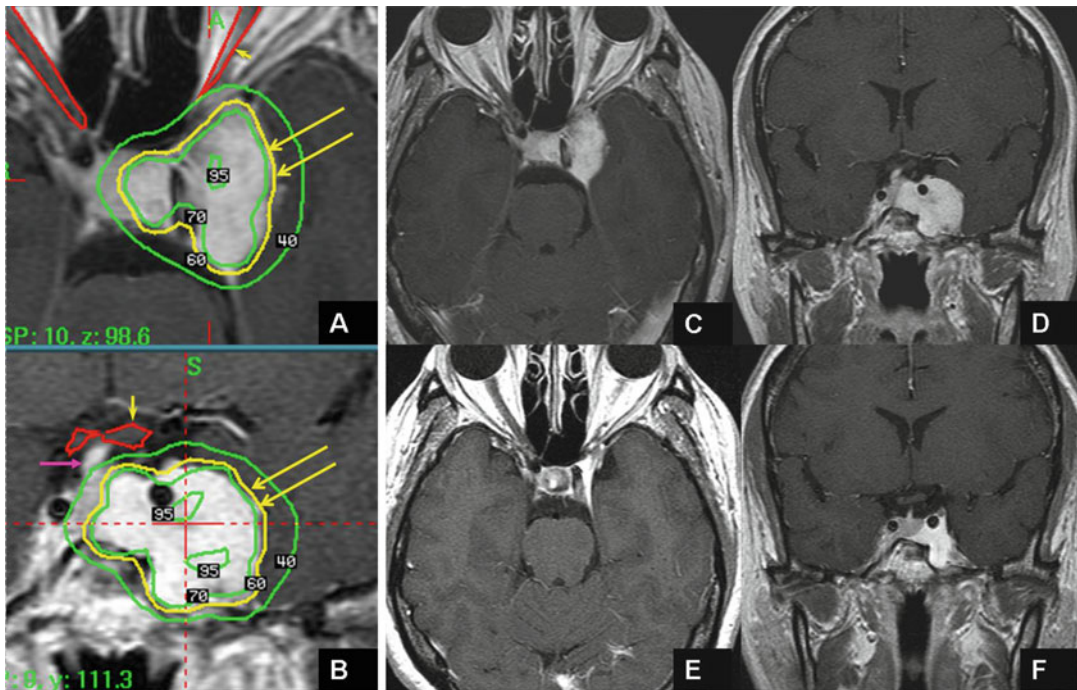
(a): Radiation dose plan for a patient with a left CS hemangioma. This 46-year-old woman had double vision and headache before treatment. During radiosurgery, the treatment plan on axial MRI demonstrated a conformal radiation field covering the tumor margin at the 60% isodose level (yellow line). The dose to the tumor margin was prescribed as 12 Gy. The optic nerves were outside the 40% isodose level, and received less than 8 Gy of radiation (yellow arrowhead). (b): Coronal T1-weighted image with contrast enhancement in the same patient showing the optic chiasm was pushed upward
